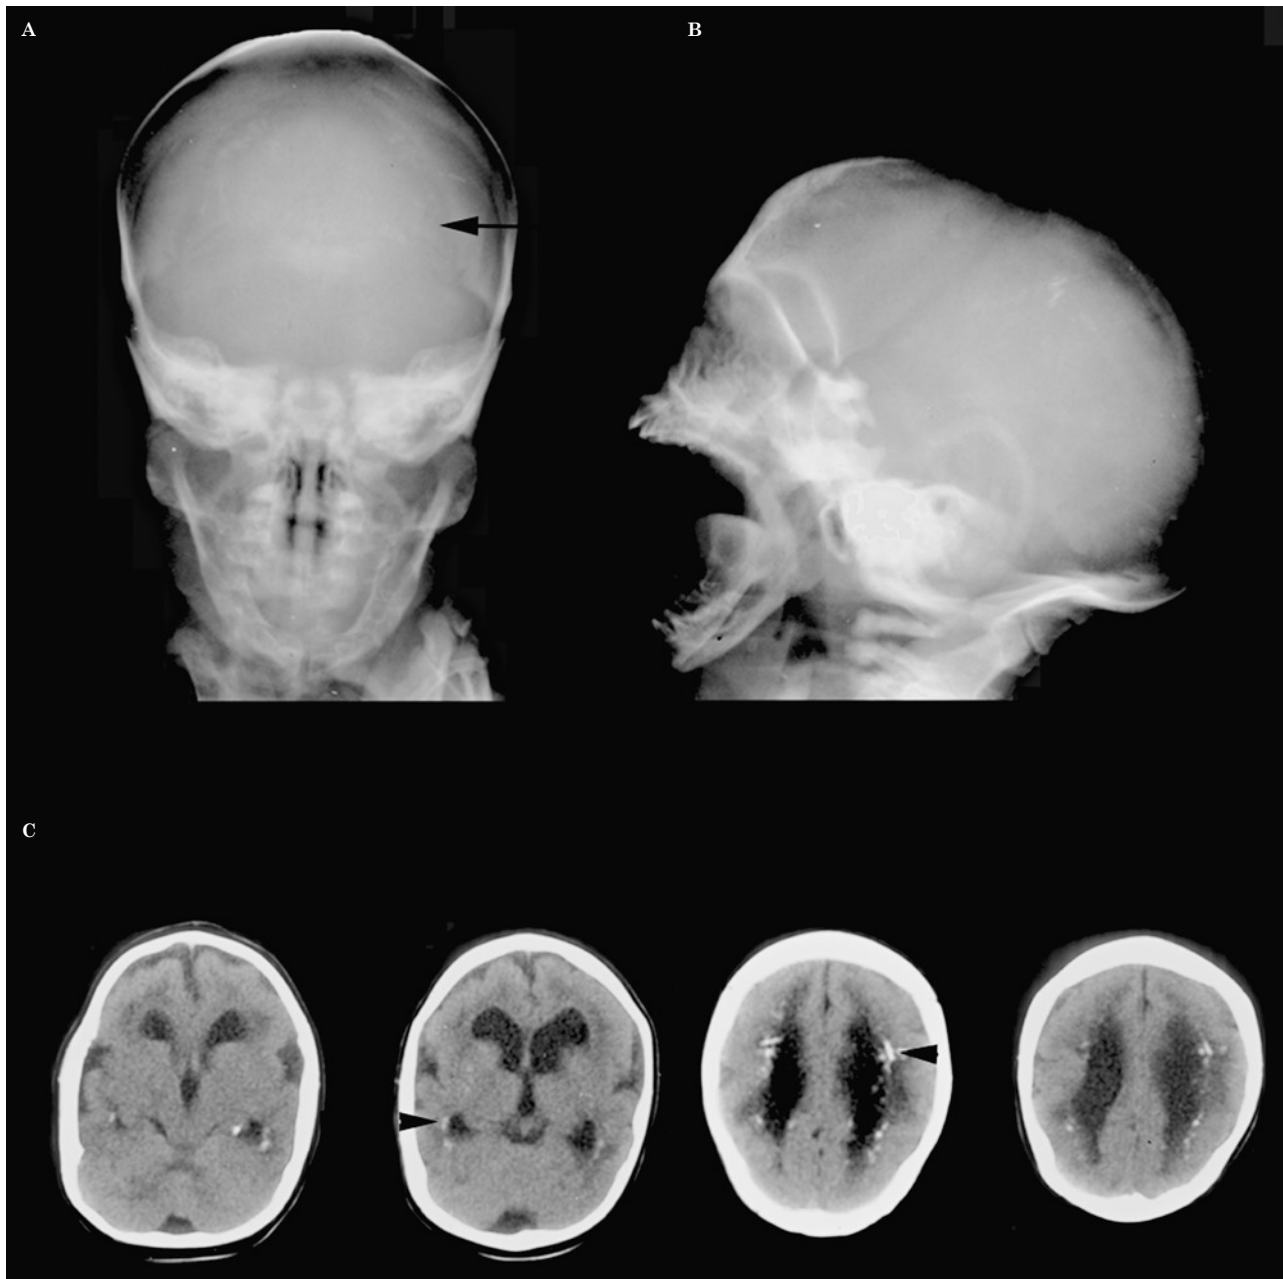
CMV infection. Frontal (A) and lateral (B) radiographs of an infant's skull reveal coarse calcifications (arrow) in the expected locations of the lateral ventricles. C) Non-contrast CT demonstrates the typical calcifications (arrowheads) deposited just beneath the ependyma of the ventricles.
